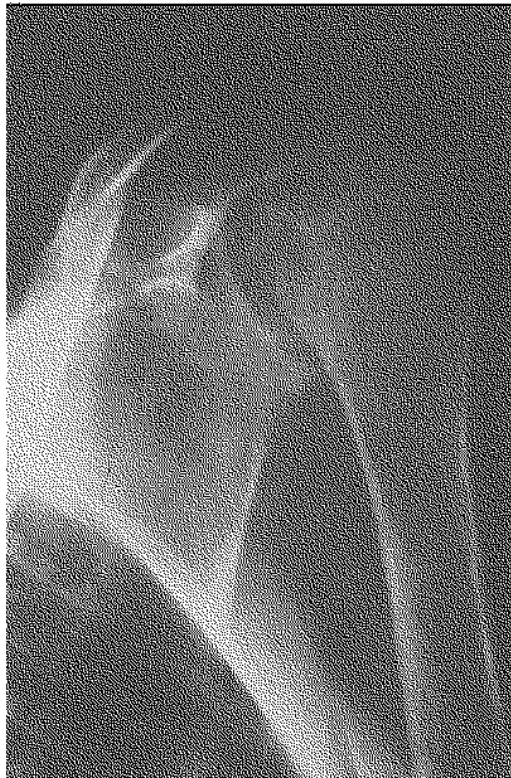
Severe destruction of the shoulder on the radiograph at the time of admission.
